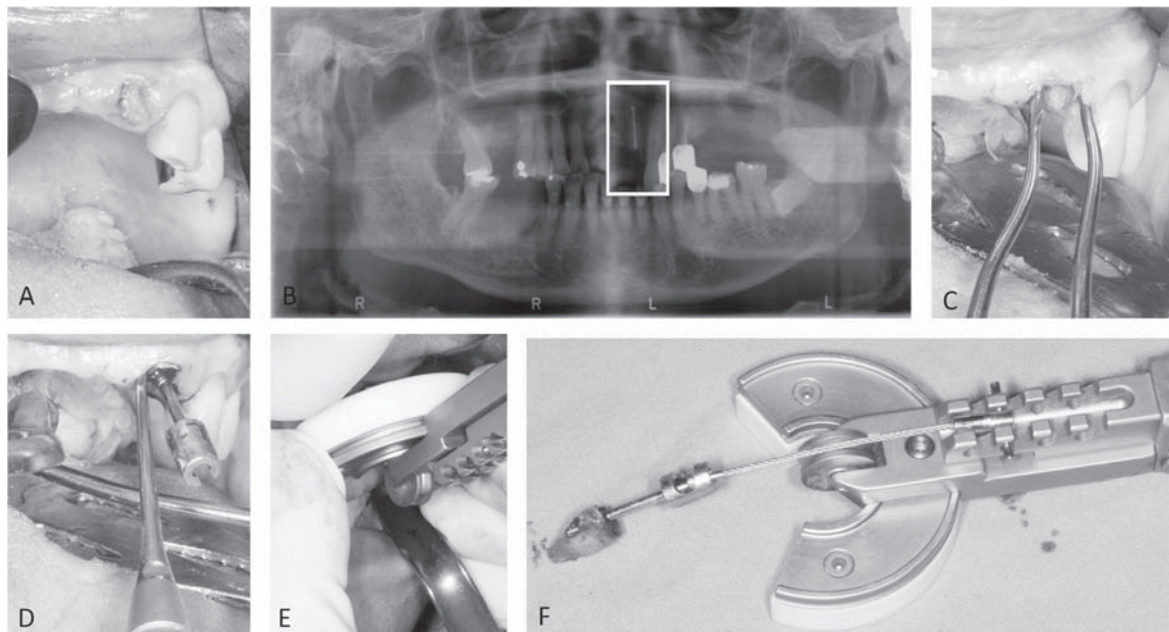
A. A decayed maxillary left lateral incisor with remaining residual root. B. Panoramic radiograph shows previous root canal treatment. C. Minimal invasive periosteal elevator for periodontal ligament detachment. D. Pilot hole preparation into the canal and placement of screw into the root. E. Support tray and assembled vertical tooth extraction system to achieve axial alignment. F. Extracted root.
